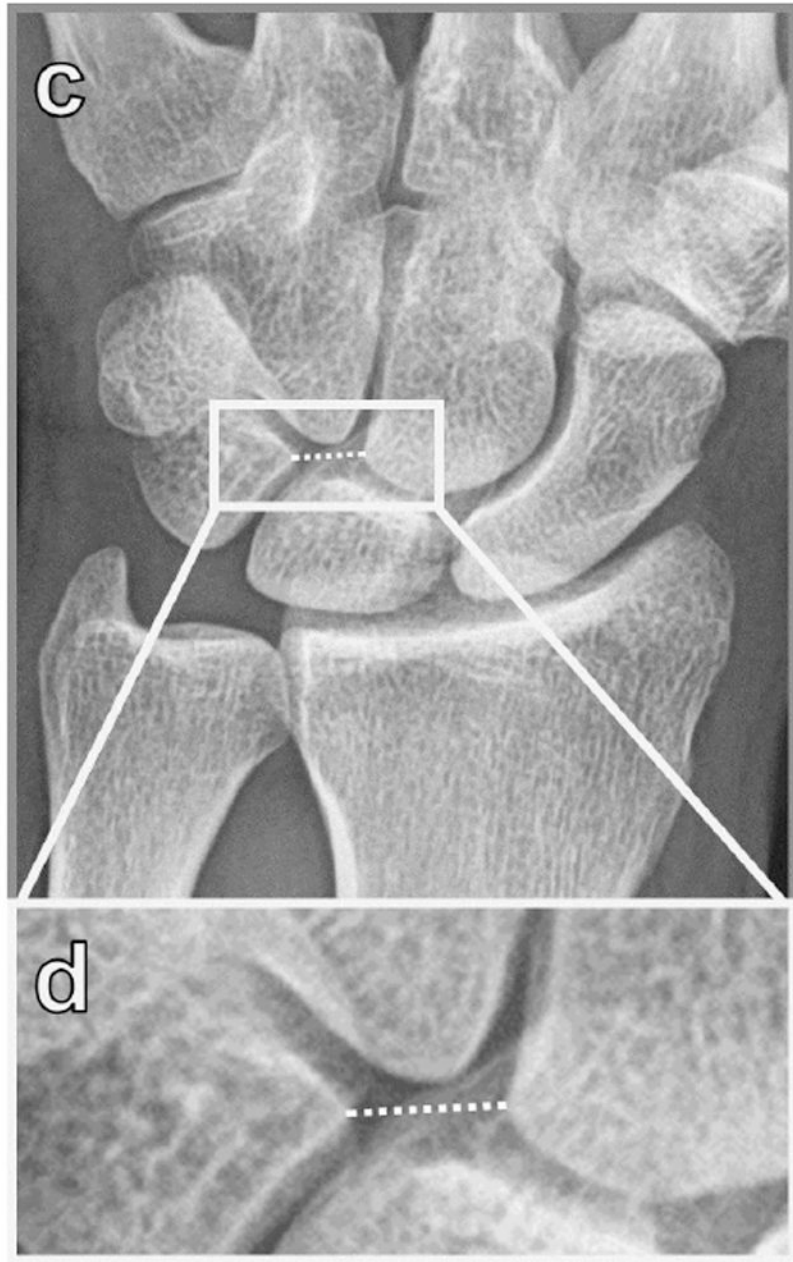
Twenty-one-year-old man with full-thickness LTIL tear indicated by arrows on (a) arthrogram and (b) coronal fat-suppressed T1-weighted MR arthrogram
